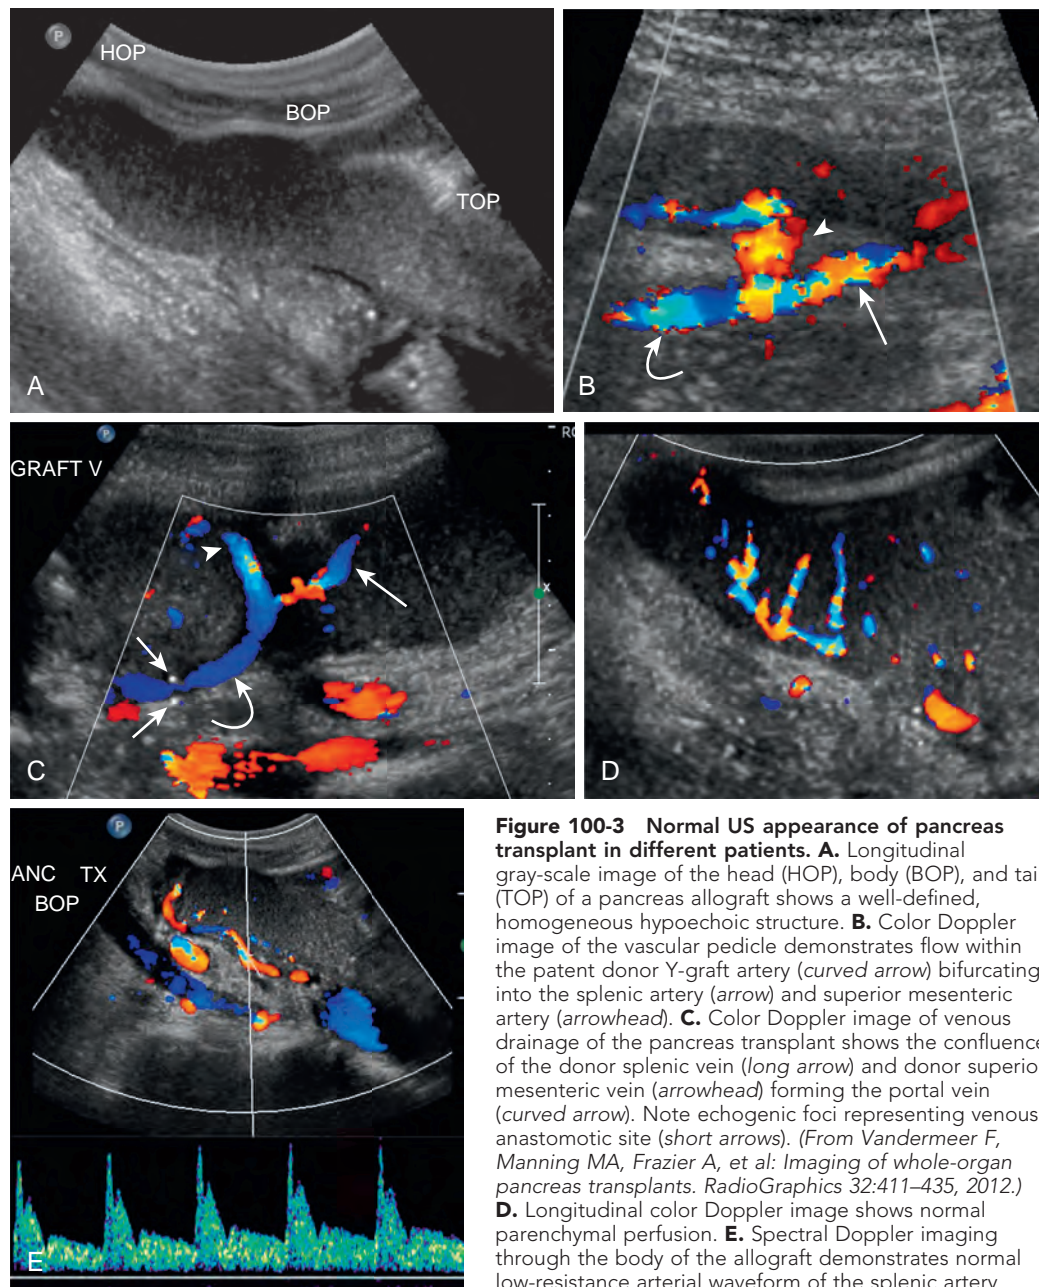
Normal US appearance of pancreas transplant in different patients. A. Longitudinal gray-scale image of the head (HOP), body (BOP), and tail (TOP) of a pancreas allograft shows a well-defined, homogeneous hypoechoic structure. B. Color Doppler image of the vascular pedicle demonstrates flow within the patent donor Y-graft artery (curved arrow) bifurcating into the splenic artery (arrow) and superior mesenteric artery (arrowhead). C. Color Doppler image of venous drainage of the pancreas transplant shows the confluence of the donor splenic vein (long arrow) and donor superior mesenteric vein (arrowhead) forming the portal vein (curved arrow). Note echogenic foci representing venous anastomotic site (short arrows). (From Vandermeer F, Manning MA, Frazier A, et al: *Imaging of whole-organ pancreas transplants*. *RadioGraphics* 32:411–435, 2012.) D. Longitudinal color Doppler image shows normal parenchymal perfusion. E. Spectral Doppler imaging through the body of the allograft demonstrates normal low-resistance arterial waveform of the splenic artery.
